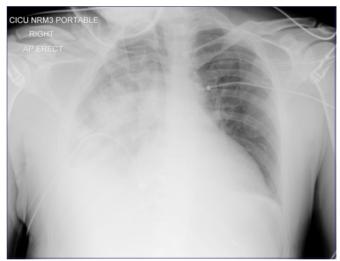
This chest radiograph shows extensive opacification in the right lung field consistent with a pulmonary contusion. There are multiple rib fractures and a right sided chest drain in situ.
